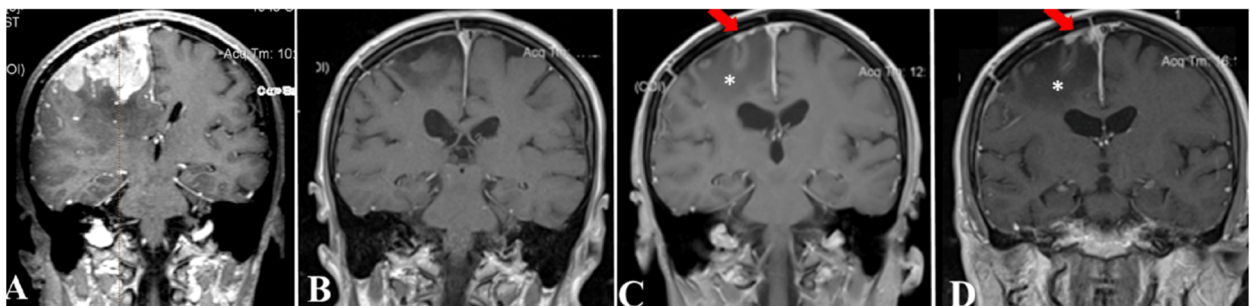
Female, 65-year-old: (A) Right parasagittal meningioma invading the middle third of the SSS (T1 + contrast); (B) T1WI + contrast MRI at one year showing no recurrence; T1WI + contrast MRI at two years (C) and three years (D) of follow-up showing tumor recurrence (red arrows). MRI: Magnetic resonance imaging; SSS: Superior sagittal sinus; T1WI: T1 weighted.
